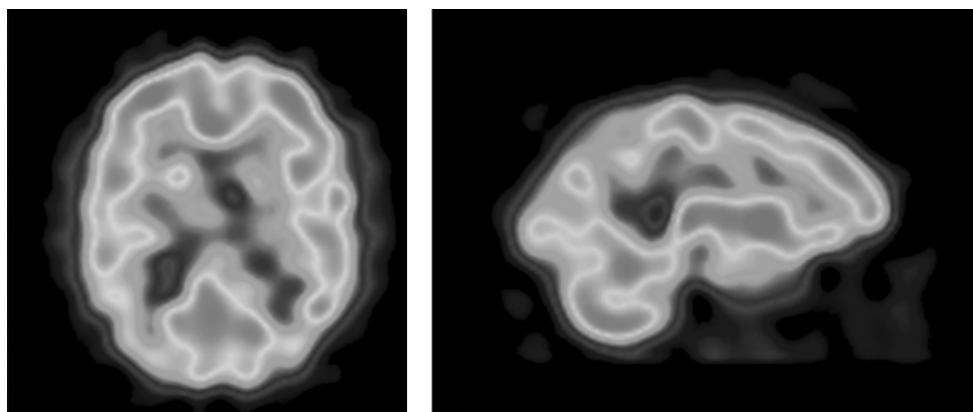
FDG-PET showing parietal and occipital hypometabolism in a patient affected by dementia with Lewy bodies. (Courtesy: Drs Andrea Varrone and Sabina Pappatà, Institute of Biostructure and Bioimaging, CNR, Naples.) (See color plate section.)
